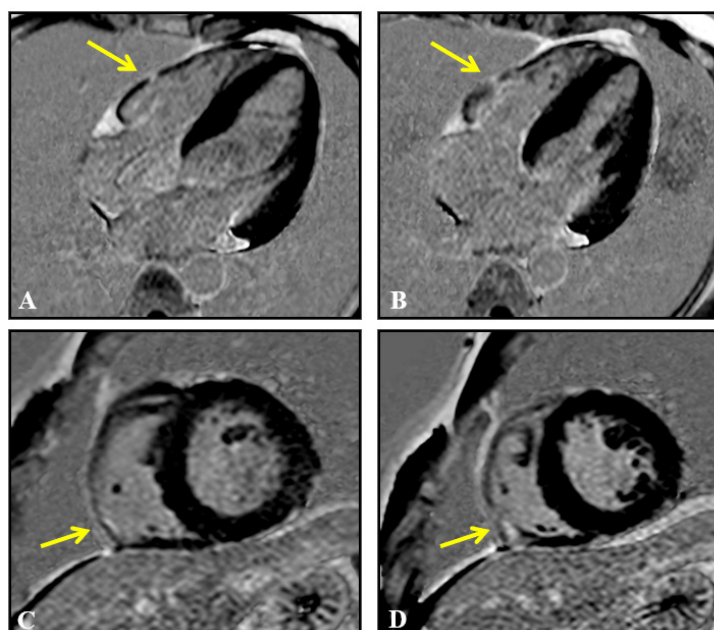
Cardiac magnetic resonance imaging, late gadolinium enhancement sequences, 4 chambers (A and B) and short axis (C and D), showing areas of pathological late enhancement in the myocardium of the inferior-lateral segment of the right ventricular free wall (arrows), without associated left ventricular involvement.
